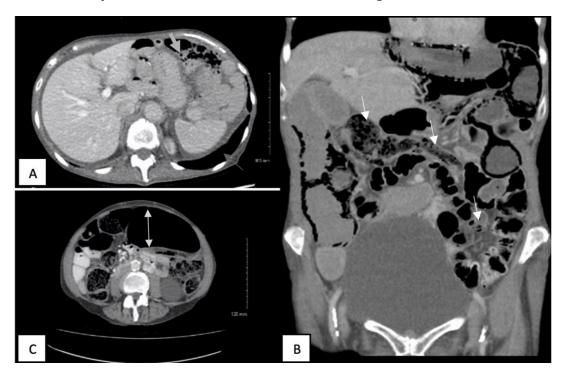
(A): CT abdomen: Pneumatosis in a left quadrant small bowel loop with adjacent small vessel mesenteric venous gas (thick arrow). New small volume pneumoperitoneum (thin arrow). (B, C) CT abdomen: Interval progression of small bowel pneumatosis (single head arrows) and new small bowel dilatation (double headed arrow).
